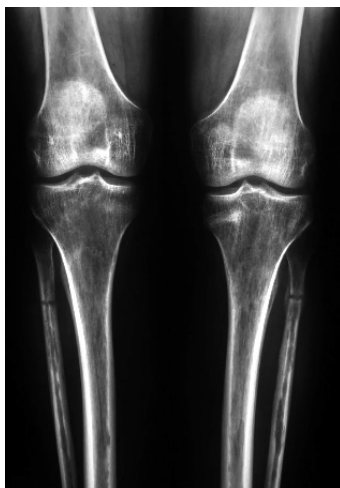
X-ray of the lower limbs — symmetrical fractures of both fibulas
